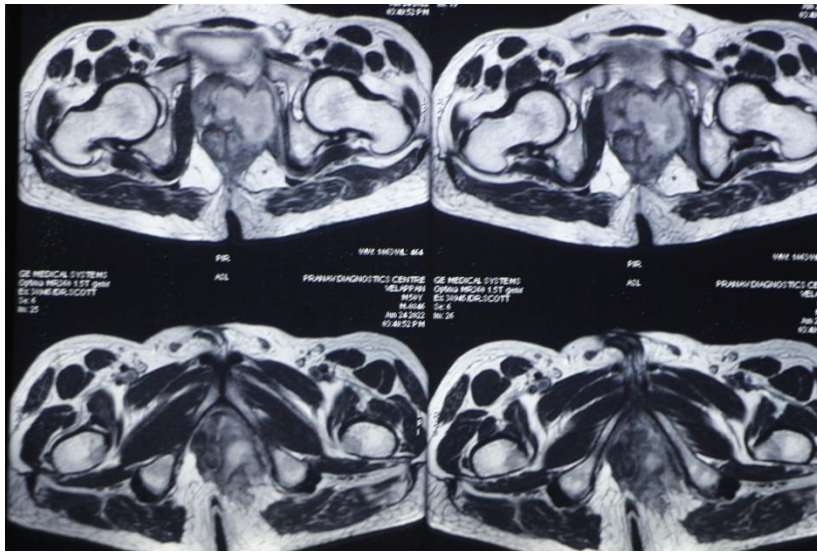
MRI perianal area T₁ Axial image shows Perianal abscess secondary to ruptured prostatic abscess
